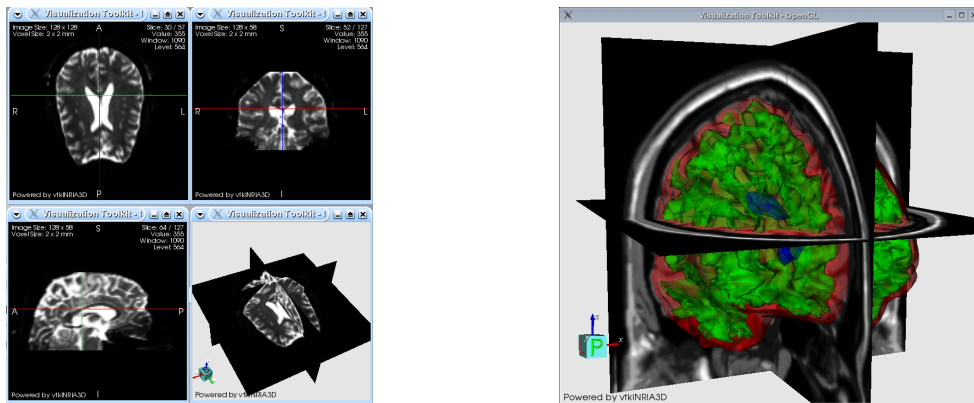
Snapshots of vtkINRIA3D. Left: Four views of a 3D brain MR image are shown. Thanks to the vtkINRIA3D synchronization view framework, an interaction in one view (i.e. a change of the slice position, the image contrast or the zoom level) will have the same effect on the other views. Right: In this figure some isosurfaces of brain structure segmentations are visualized on top of an MRI image.
